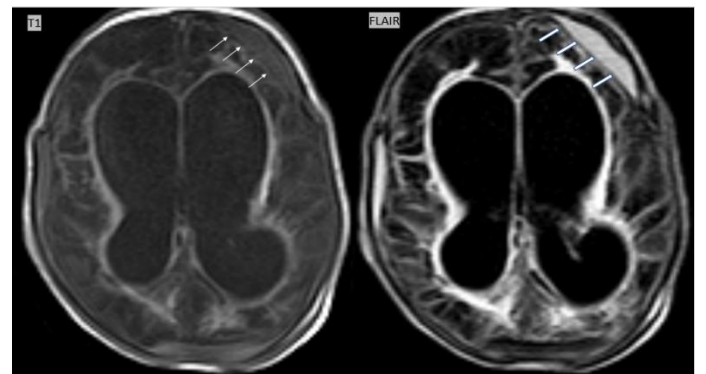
Axial T1 and FLAIR image shows chronic subdural hematoma in left frontal region with diffuse cystic encephalomalacic changes causing exvacuo dilation of bilateral lateral ventricles
